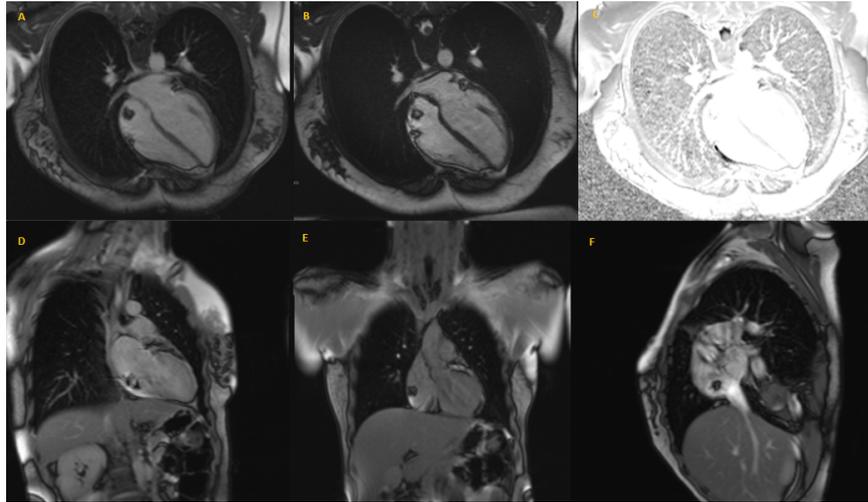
Cardiac magnetic resonance imaging
